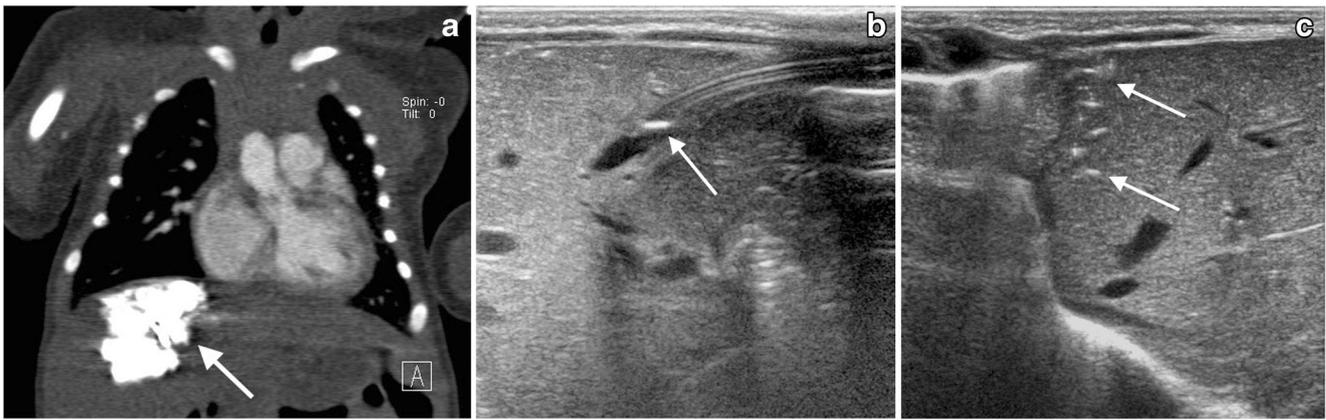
Hypoplastic aortic arch in a 6-day-old boy. a Coronal image from a cardiac computed tomography (CT) scan (with injection of contrast agent performed via an umbilical venous catheter) shows contrast agent pooling within the liver parenchyma (*arrow*). b Transverse image from an ultrasound performed the next day demonstrates the umbilical venous catheter tip (*arrow*), low lying within the umbilical vein as it enters the liver. The catheter tip did not perforate the vessel wall. During scanning
